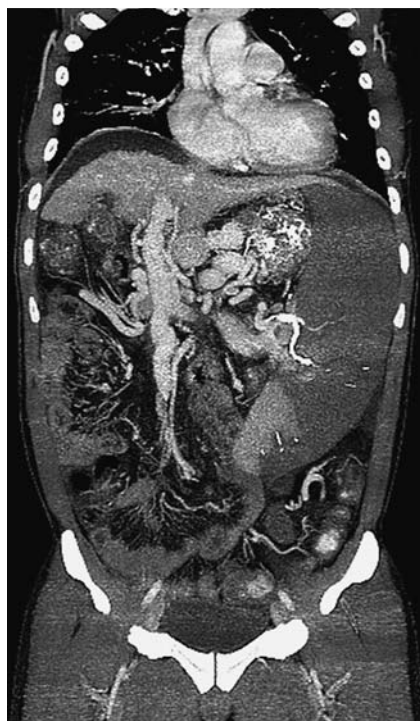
Abdominal computed tomographic angiography showing multiple cyanoacrylate deposits along the splenic vein, and an enlarged spleen and unenhanced splenic parenchyma compatible with cyanoacrylate-induced splenic infarction.
